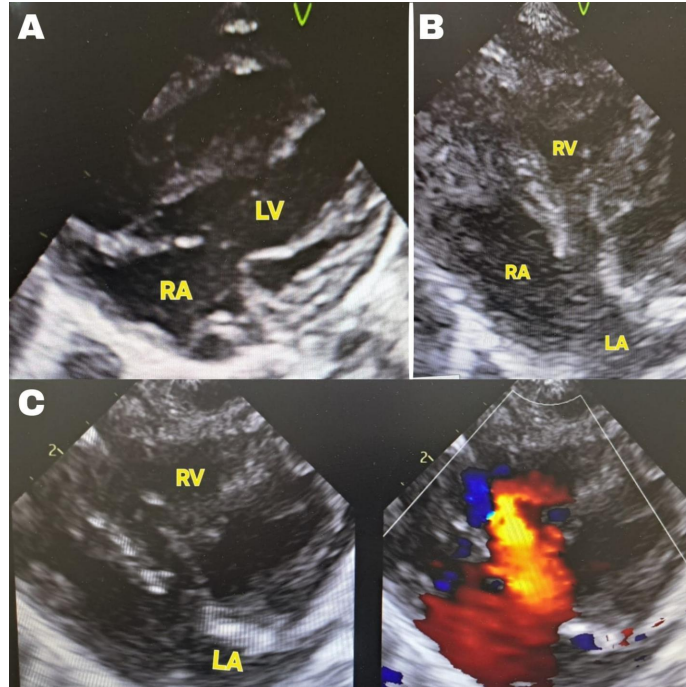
2D images of the same case. (a) A small LA drains through a tunnel-like structure into a small RV with a large ASD. (b) with colour doppler. (c) RA empties in the left ventricle.
